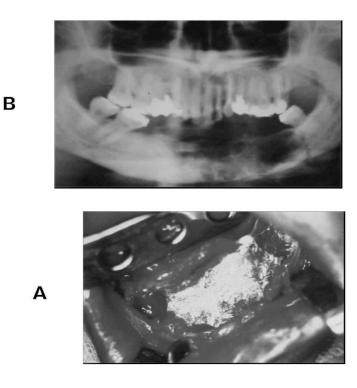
A) Frozen bone after liquid nitrogen application. And Panoramic radiograph 10 weeks after the surgery. B)Image suggestting pathological fractures in the left molar region Teeth within the lesional area were extracted. (André Caroli Rocha et la.,2009)
